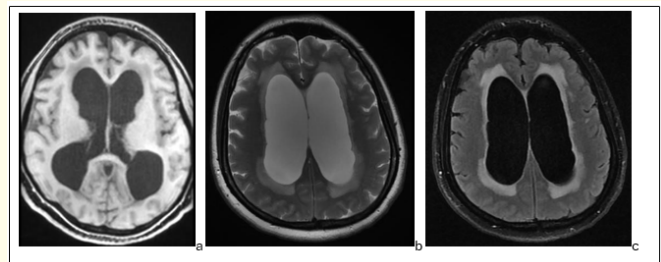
Preoperative axial sections of Cranial MRI; a T1WI, b. T2WI, c. FLAIR.
